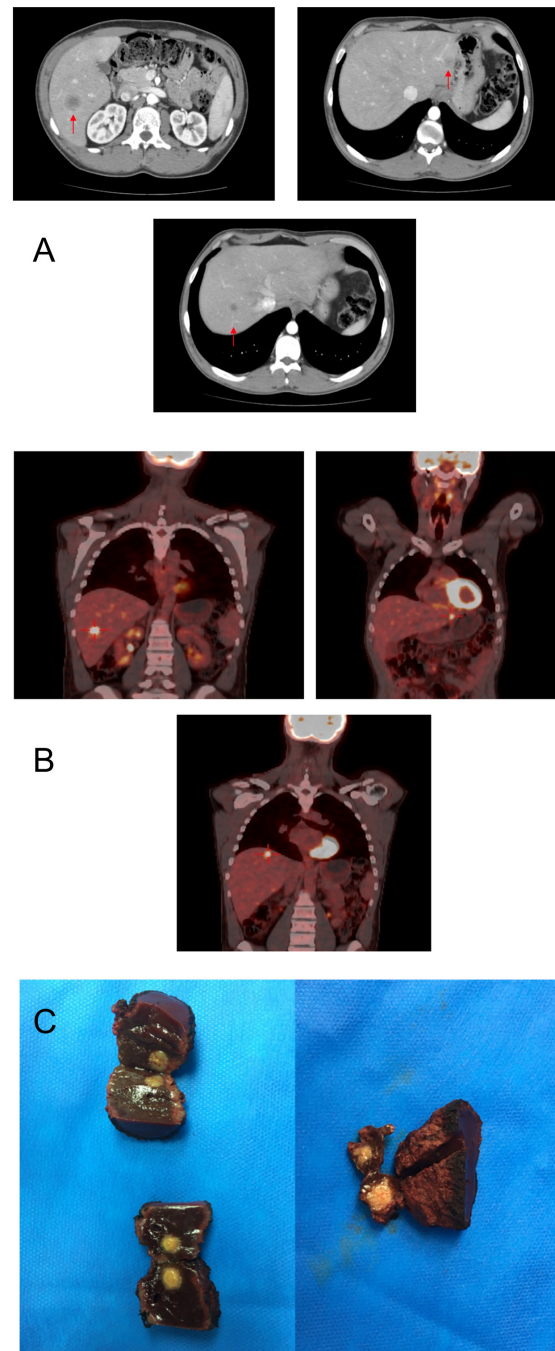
(A) Computed tomography (CT) scan showing an axial view of the hepatic lesions, presenting as non-enhancing hypodense nodules; (B) Hepatic nodules showing intense FDG uptake after PET-CT scans; (C) Liver parenchyma surrounding the three hepatic lesions removed.
